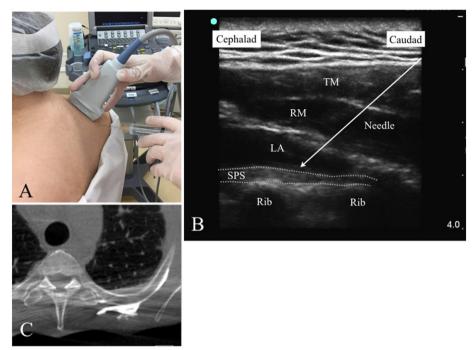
(A) Probe setting and needle insertion at the medial margin of the scapula. (B) Ultrasound image of undertaking SPS block. The needle is advanced to the top of 2nd rib (white arrows) and the local anesthetic agent (LA) is spreading between rhomboid muscle (RM) and serratus posterior superior muscle (SPS). (C) Cross-sectional image of chest computed tomography scan after SPS block. The mixture of local anesthetic agent and contrast medium was confirmed over the SPS muscle and lateral side of the thorax.
